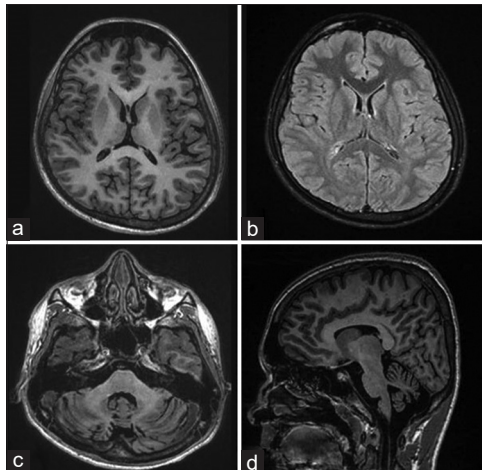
MRI T1 (a) and T2 FLAIR axial (b) show normal cerebral parenchyma; reveals cerebellar atrophy in T2 FLAIR axial (c) and T1 sagittal image (d)
